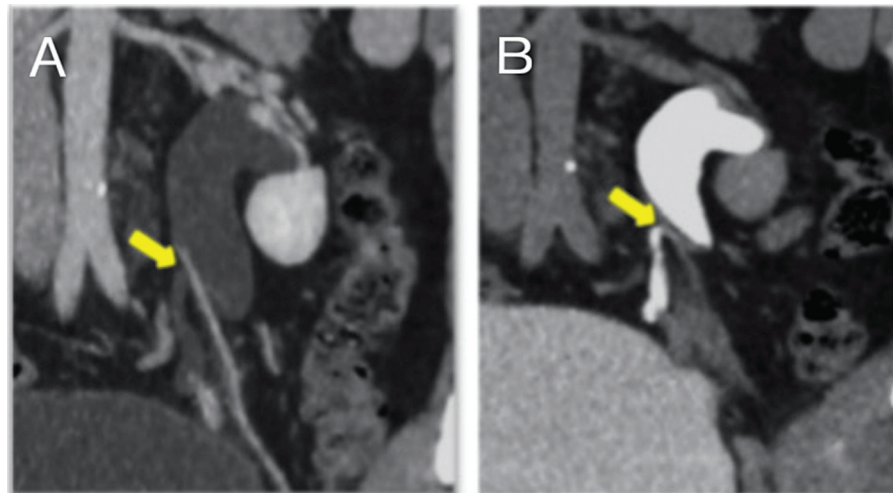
CECT-KUB (venous and excretory phases) coronal section at the level of left testicular vein crossover. CECT-KUB, contrast-enhanced computed tomography kidney, ureter, and bladder.
